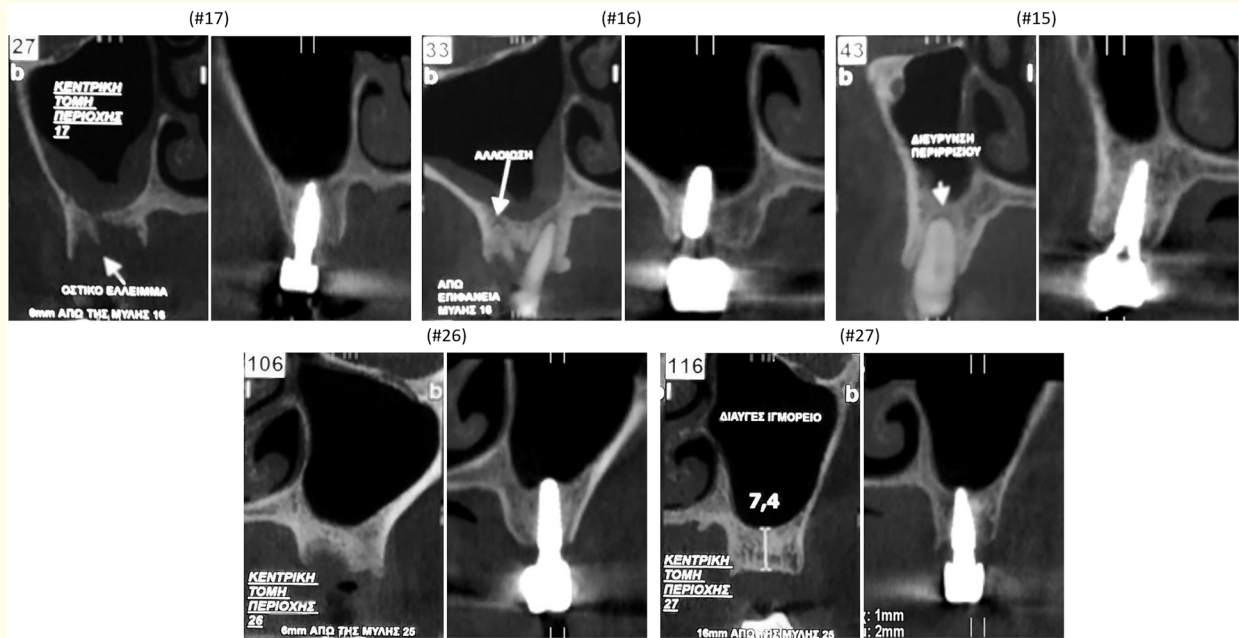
Initial and final CBCT cuts for each position of all 5 implants.
